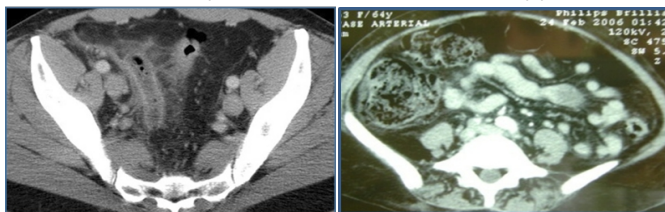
(A) shows contrast-enhanced computed tomography
